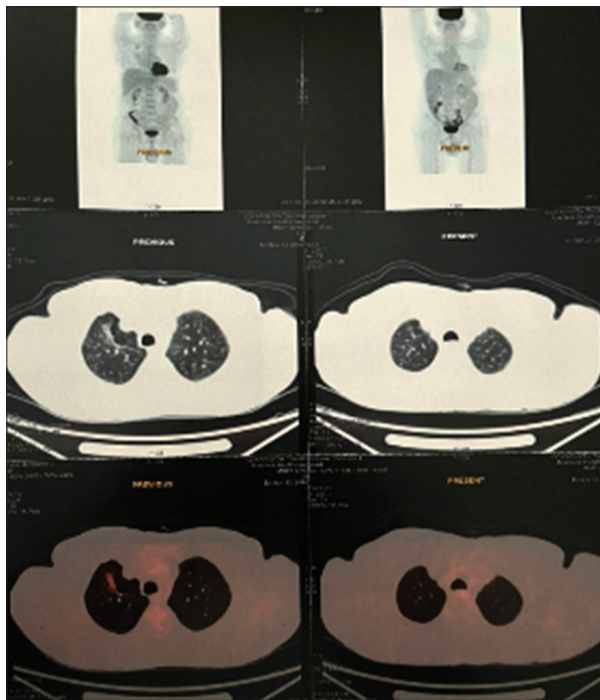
End of Treatment positron emission tomography-computed tomography - shows complete metabolic response (Deauville score 1)
